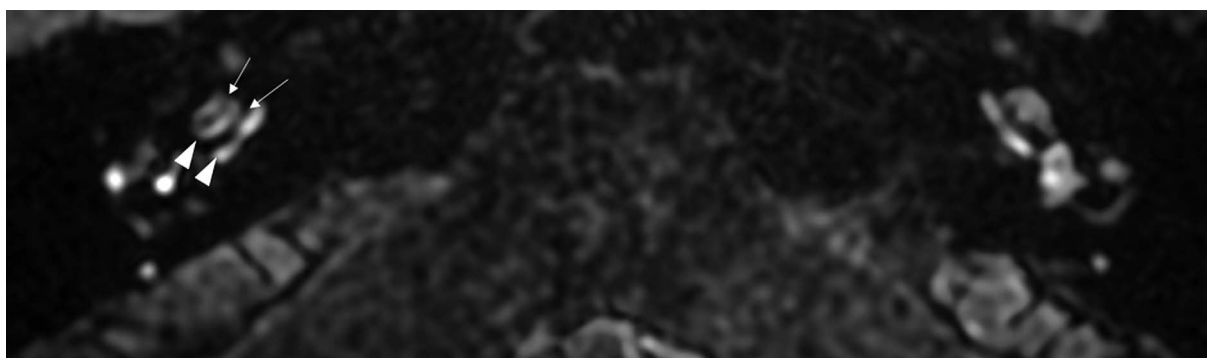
Magnetic resonance image of a 53-year-old female (patient #3) with right-sided clinically defined Ménière's disease. According to the Barath classification [11], it is an example case of grade 2 cochlear hydrops. Delayed-postcontrast 3D-FLAIR T2 axial image of both ears at the level of the cochlear modiolus. On the right side, a non-enhancing widened cochlear duct (marked with arrows) completely obstructs scala vestibuli, enhancing scala tympani (marked with arrowheads) resembling stripes
